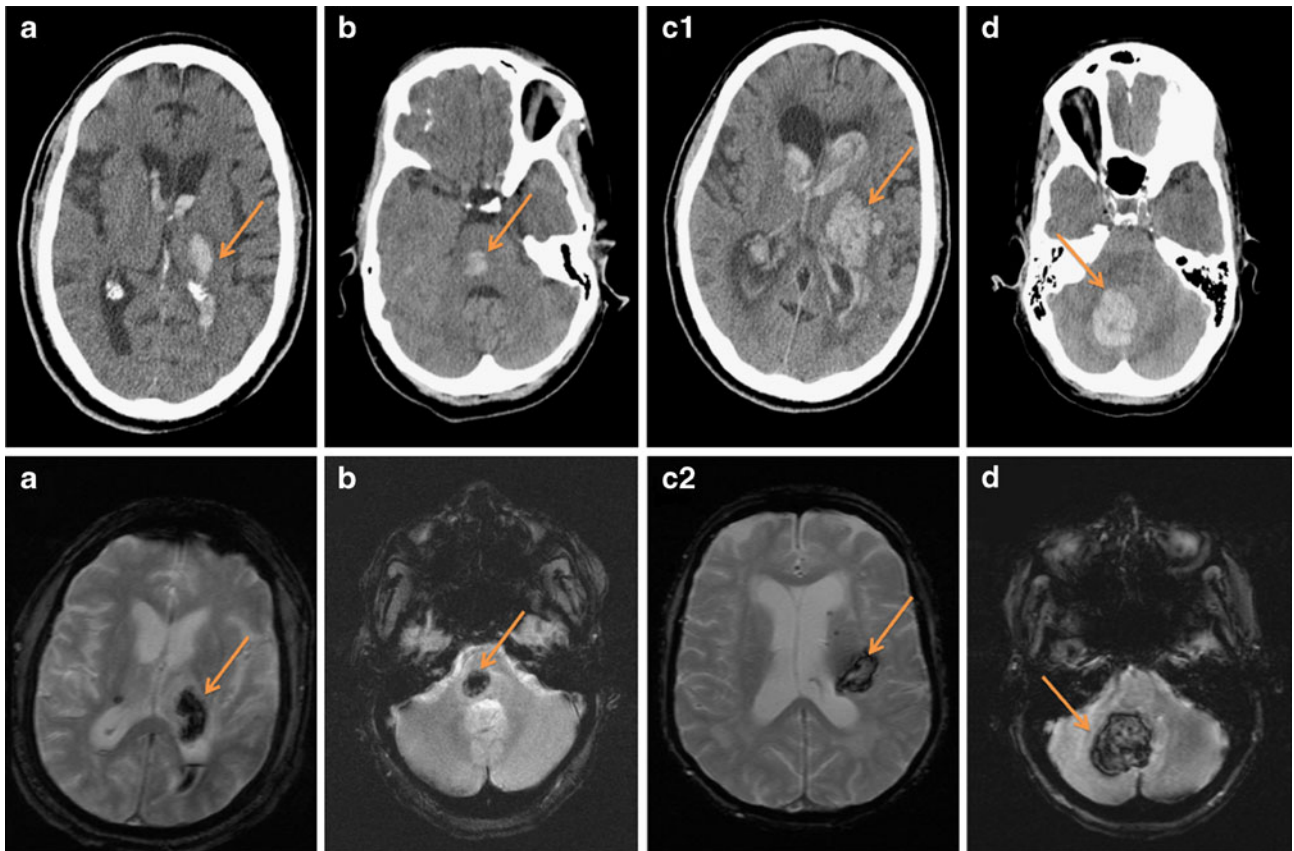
Examples of primary intraparenchymal hemorrhage (arrows). (a) Left thalamic hemorrhage [imaging modality: computed tomography (CT) and gradient recalled echo magnetic resonance imaging (GRE MRI)], (b) right pontine hemorrhage (CT and GRE), (c1) extensive basal ganglia hemorrhage with intraventricular extension (CT), (c2) putaminal hemorrhage (GRE), (d) right cerebellar hemorrhage (CT and GRE). (High resolution version of this image is available in the [electronic supplementary material](#).)
